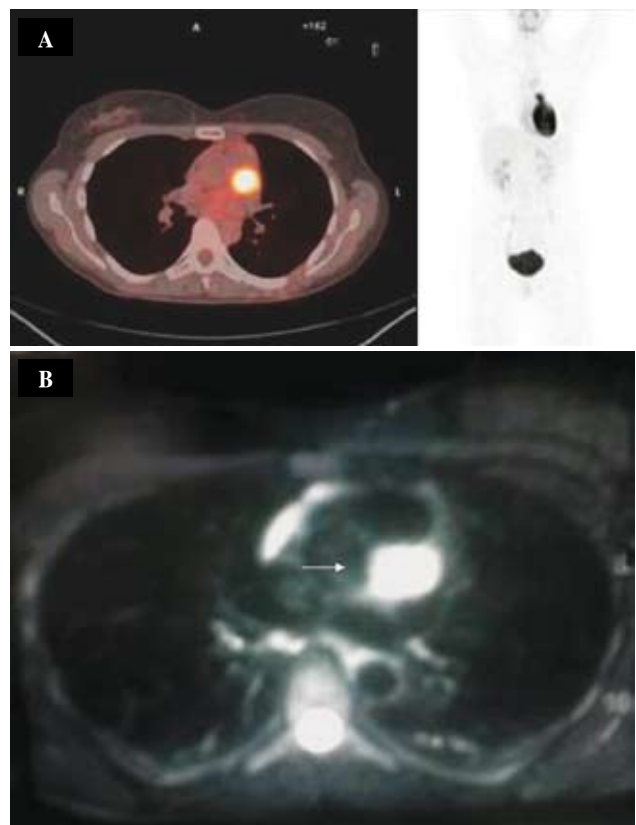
A. PET/CT: Paraganglioma detected on the epicardium, atrioventricular (AV) groove. B. MRI: High intensity lesion detected in the AV groove.
